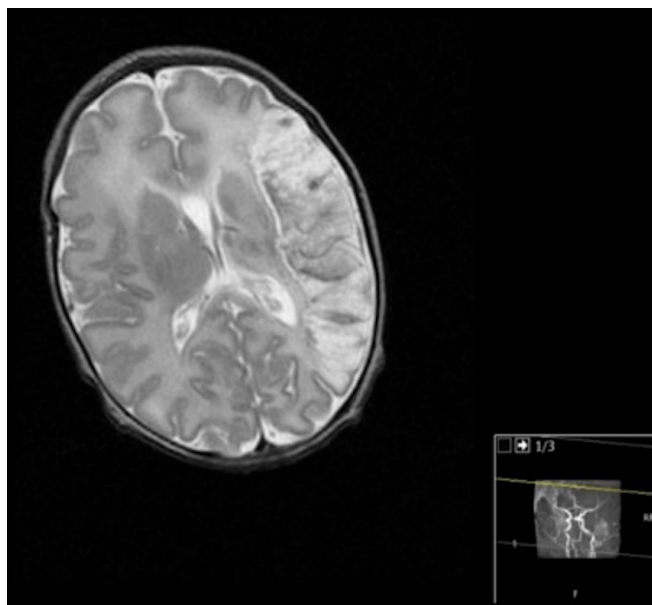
Ischemic Stroke (MCA territory) at day twelve of life- MRI T2 with an extensive lesion on left frontotemporoparietal lobes and basal ganglia.
